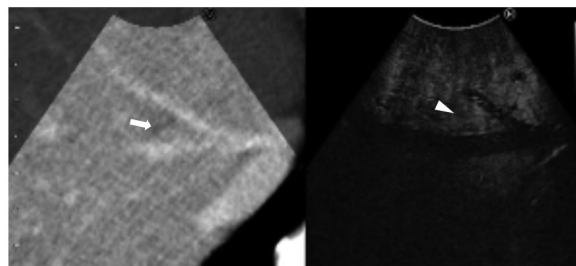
Still intraoperative real-time virtual sonography image in Case 1. Preoperative CT (left side) and contrast-enhanced intraoperative ultrasound (CE-IOUS; right side) were synchronized. The nodule was diagnosed as benign, because there was no hypo-echoic nodule at the same site on the CE-IOUS scan (arrowhead) where the low-density nodule was seen on the CT scan (arrow).
